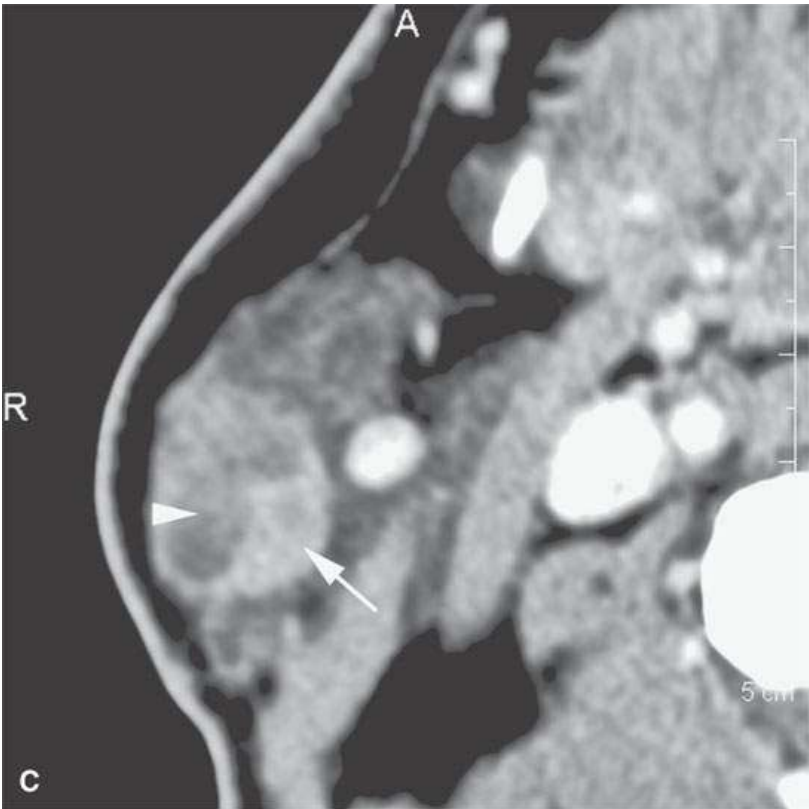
Contrast-enhanced computed tomography of patients with Warthin tumors. A: Septated (arrowhead) mainly cystic tumor (arrows) with sharp margins. B: Multiple bilateral enhancing tumors with sharp margins (arrows). C, D: Partially cystic and partially solid sharply marginated (C) tumor with slightly ill defined margin in (D). E: Multiple sharply marginated cystic and solid masses with calcification. F: Large solitary sharply marginated cystic and solid mass with calcification.
